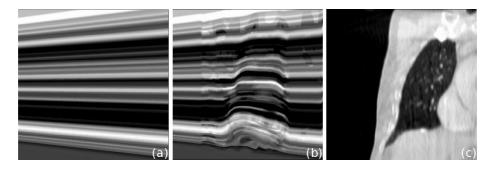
Coronal slice of one backprojection acquired at end-inhale with the panel perpendicular to the left-right axis in (a) the static case and (b) the motion compensated case. (c) Corresponding slice of the motion-compensated CBCT image of the mean position.
